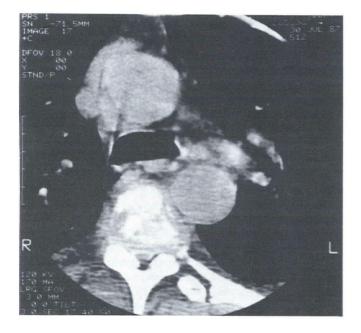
Postmyelogram computed tomography scan demonstrating soft tissue invasion of spinal elements predominantly anterior to the spinal cord.
